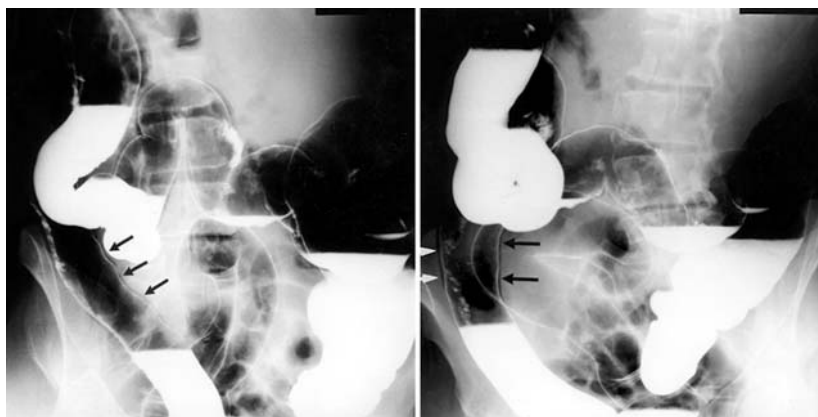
Erect radiographs from a double contrast barium enema series. Submucosal tracking of gas is arrowed.
